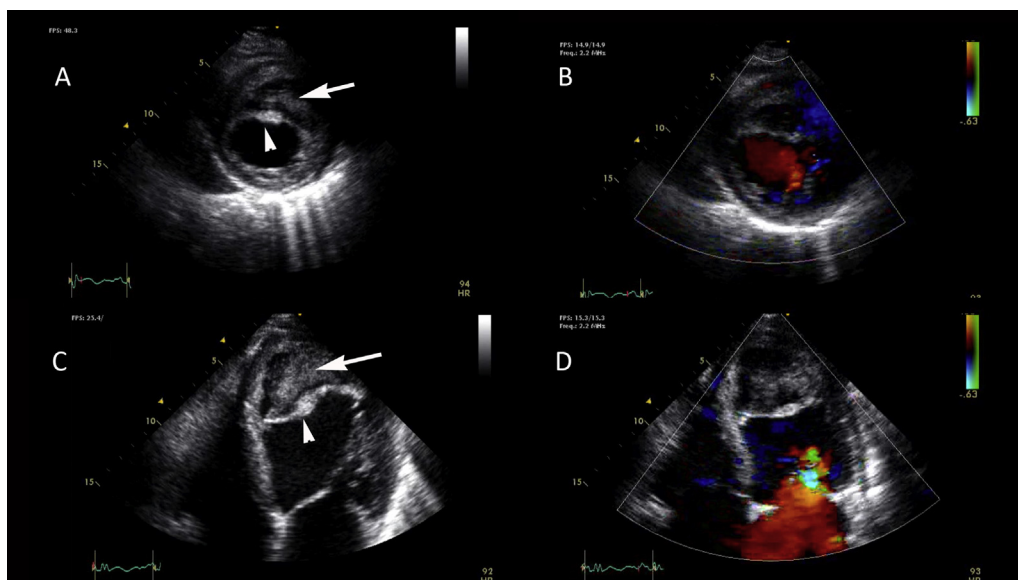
Transthoracic echocardiogram from parasternal (A,B) and apical (C,D) windows. A layer of myocardium is seen (arrowhead), starting in the distal third of the myocardium. Distal to this layer, there is mobile echodensity (arrow), consistent with thrombus. Color Doppler images (B,D) show no obvious flow within the distal cavity at the Nyquist limit of 63 cm/sec.
